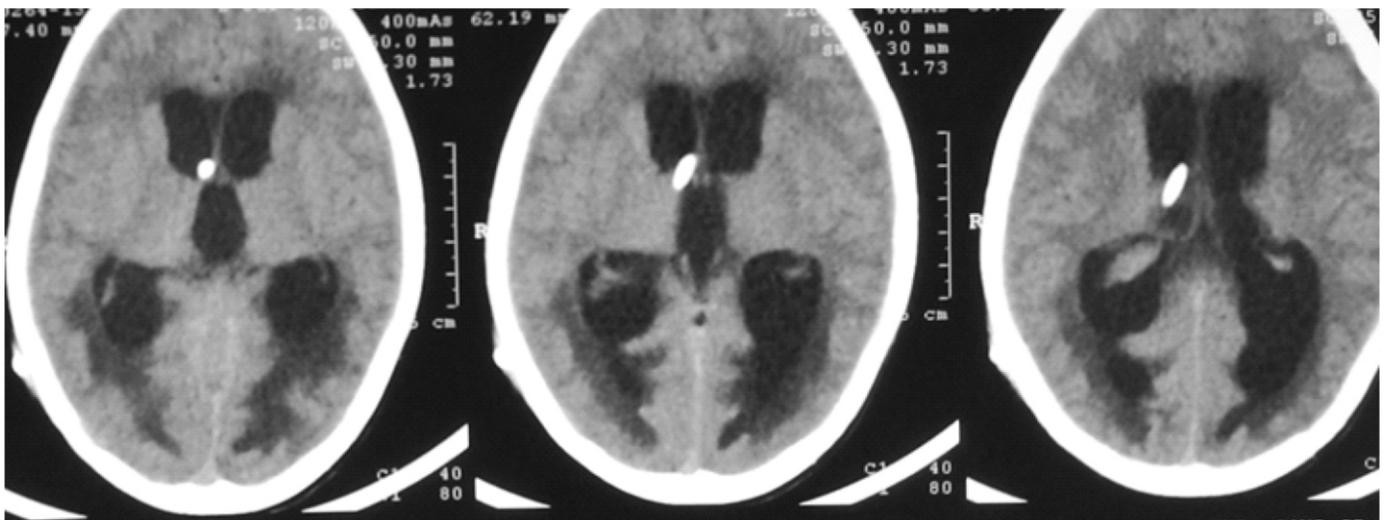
B: CT scan at the time of operation.
